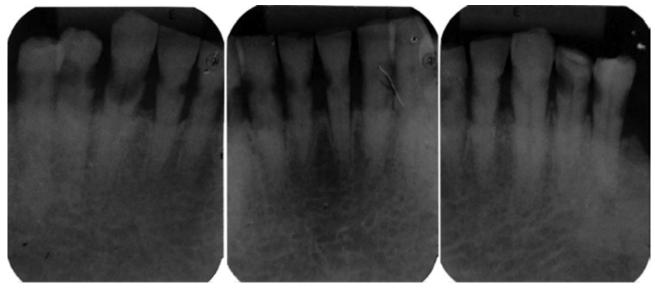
Periapical radiographs showing radiation decay of the cervical anterior lower teeth.
